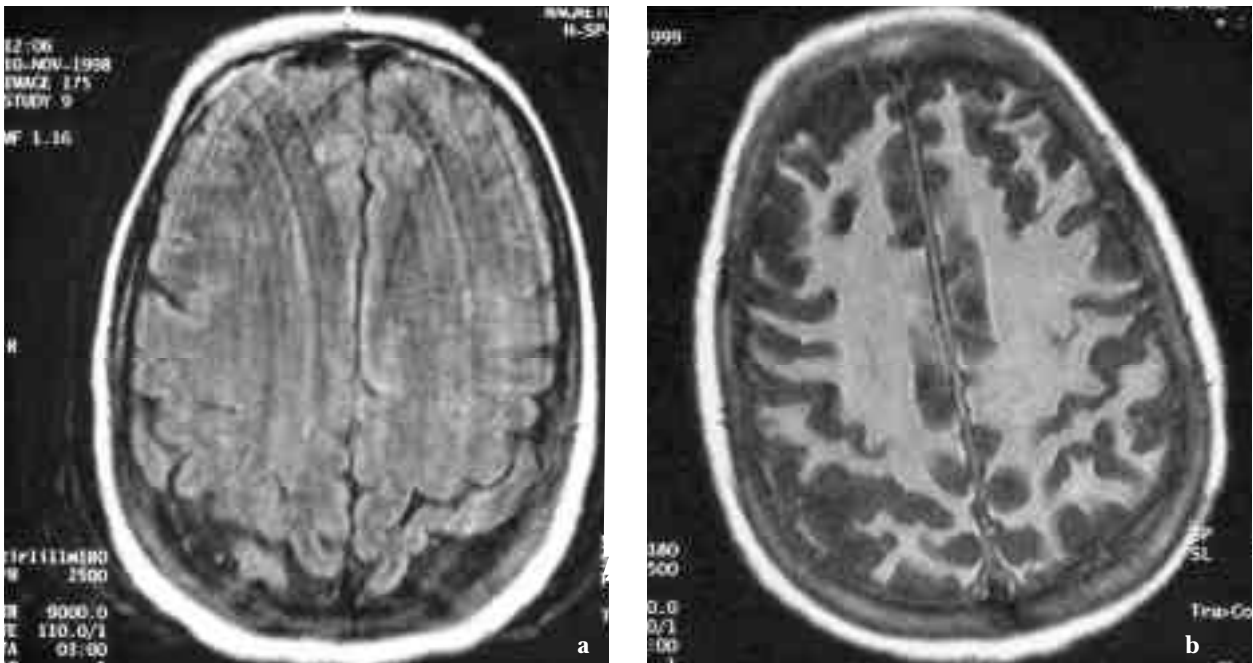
a, b: Flair sequence brain MRI, TR 9000, TE 110 TA 3 at the same level using GE 1.5 Tesla scanner showing normal brain MRI on admission (1a) and severe cortical atrophy 1 year later (1b)
